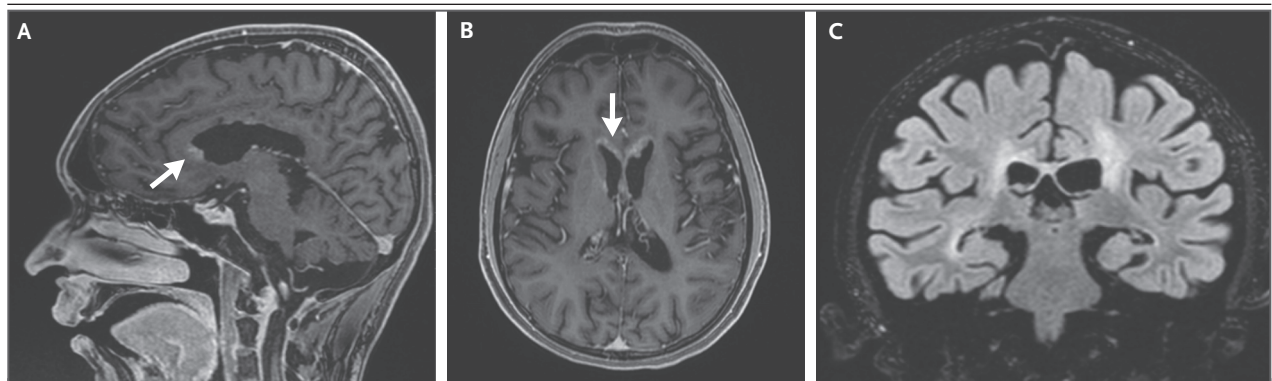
MRI of the Head.
